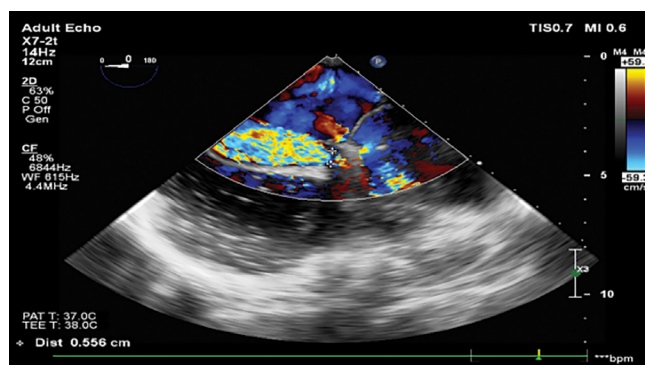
Transesophageal echocardiography image demonstrating a severe paravalvular leak localized between the 1 and 3 o'clock positions around the metallic mitral prosthesis
